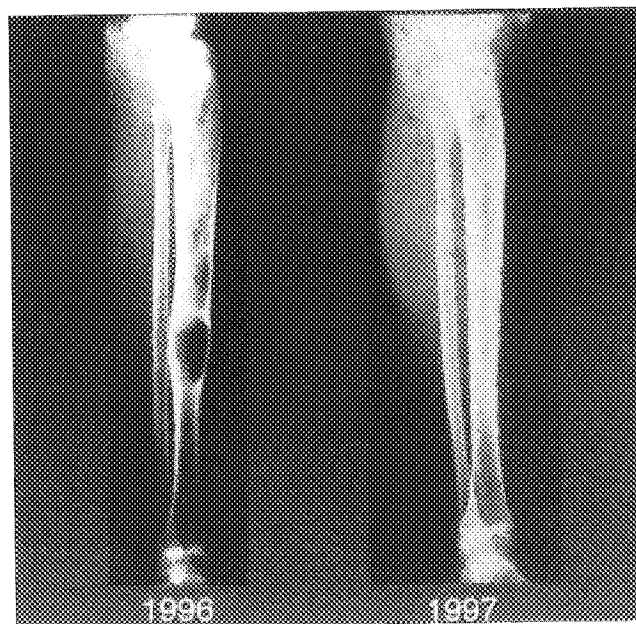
X-ray of a tibia before and after 18 months of treatment with intravenous pamidronate in a 16-year-old boy.
